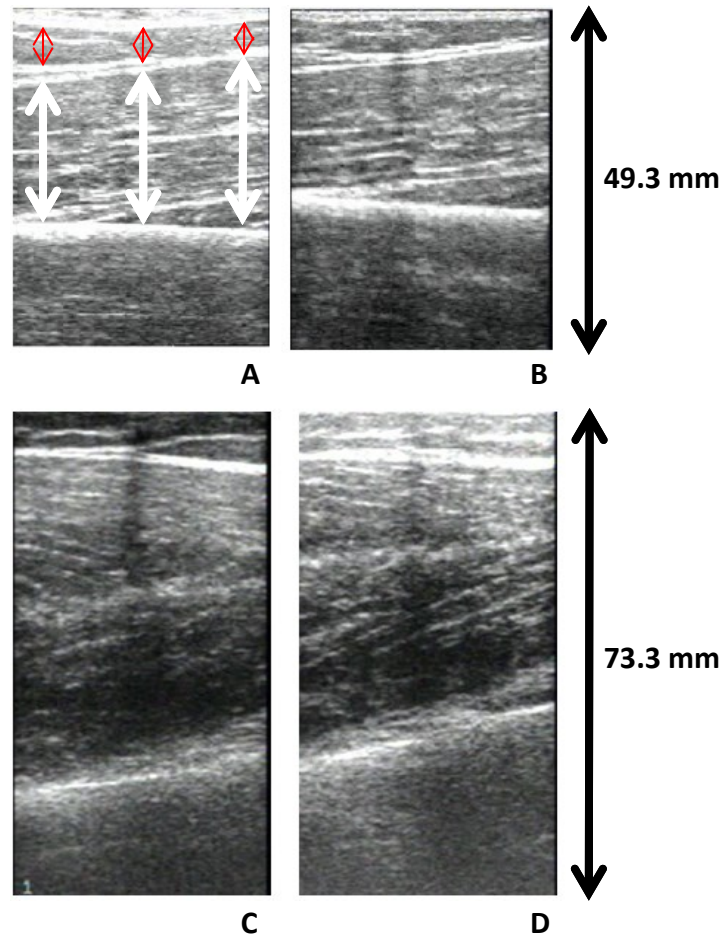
Ultrasound images of the biceps Pre- (A) and Post-immobilisation (B) and the triceps brachii Pre- (C) and Post-immobilisation (D). The red arrows indicate sub-cutaneous adipose thickness measurement sites. The white arrows indicate muscle thickness measurement sites.
